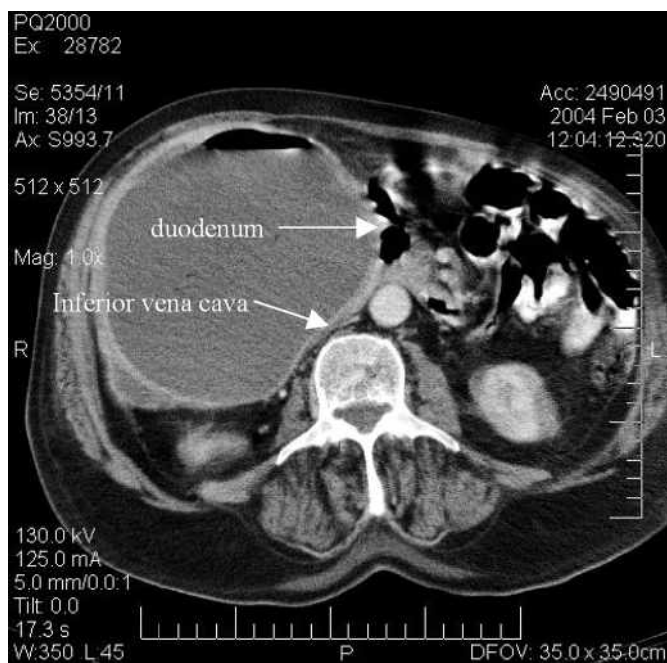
Contrast-enhanced computer tomography (CT) scan showing a huge cyst in segment five of the liver with a thickened wall showing contrast enhancement and gas formation within the cyst. The cyst is compressing the duodenum and the inferior vena cava.
